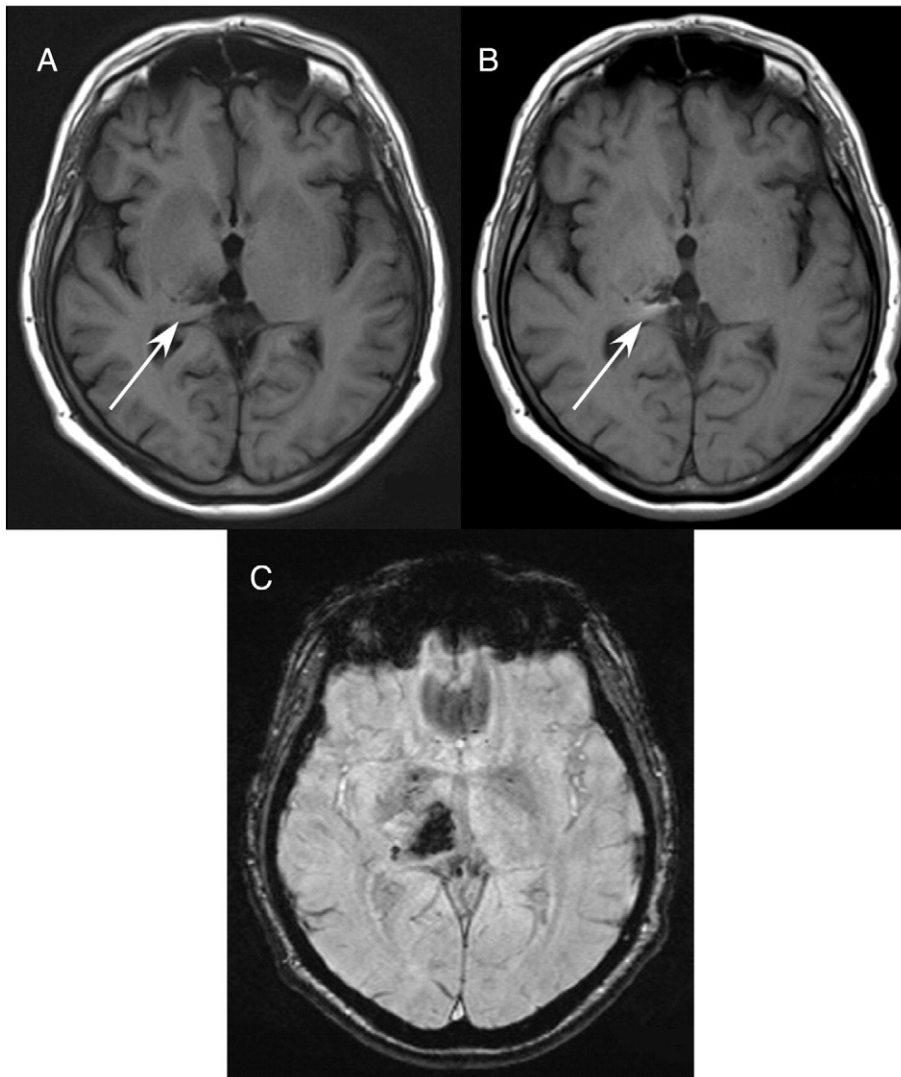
Sequences: T1W FLAIR BLADE (A), T1W SE (B), T2* (C). T1W FLAIR BLADE depicts hemorrhage equally well as T2*. The advantage is that the first one can better eliminate magnetic susceptibility artifacts caused by high signal intensity lesions. T1W SE cannot eliminate these artifacts.
